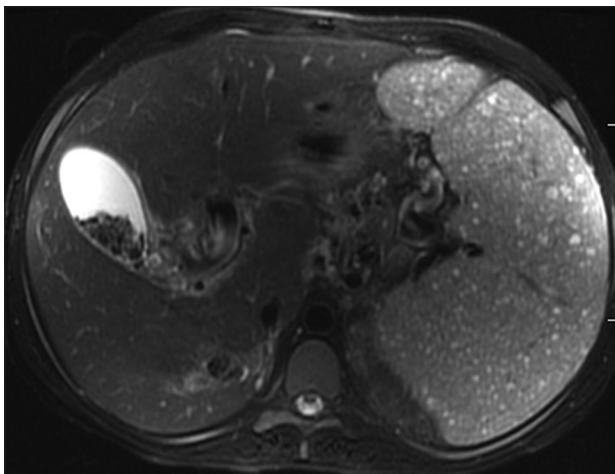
Magnetic resonance imaging T2-weighted image shows high signal intensity lesions in massively enlarged spleen. Gall stones are noted in gallbladder
